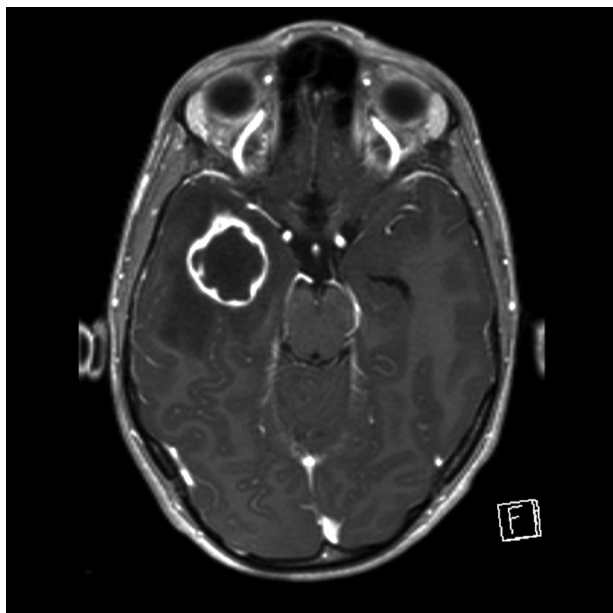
Magnetic resonance image of the patient's brain. Postcontrast, T1 weighted, axial multiplanar reformation image showing a ring-enhancing temporal-lobe lesion with hypodense core and surrounding cerebral edema.
